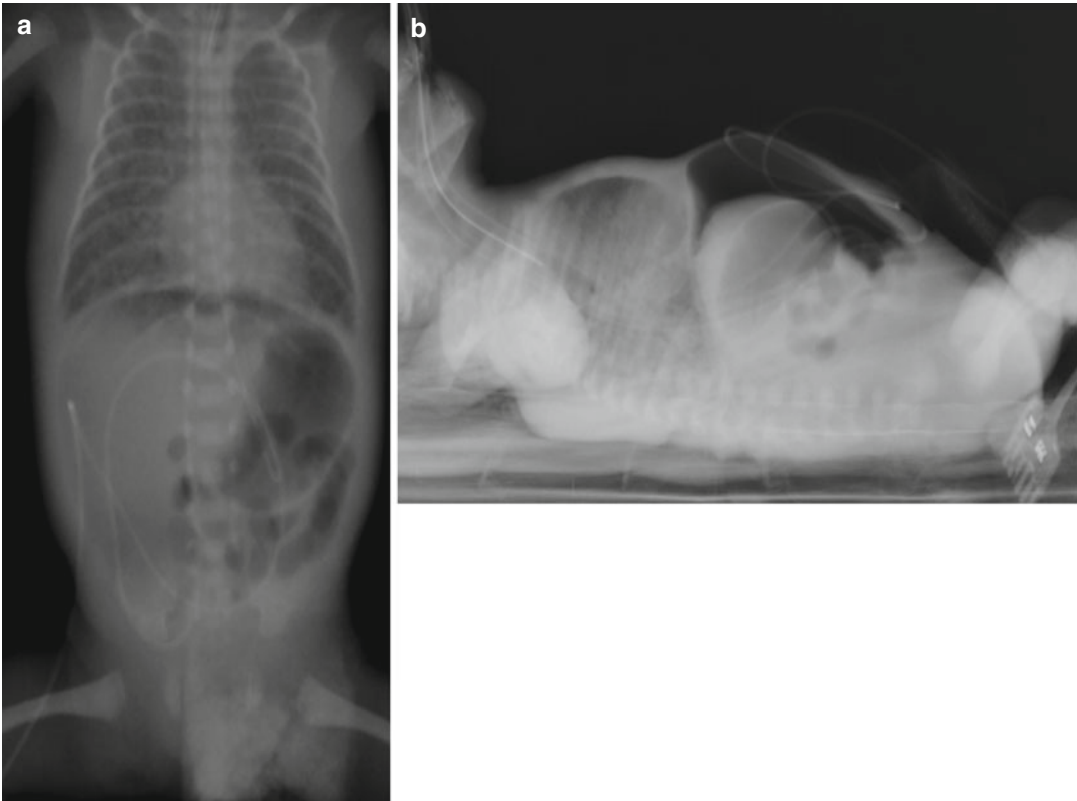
Abdominal plain film in newborn with NEC: massive pneumoperitoneum (a–b). In the frontal view (a) see the football sign and the continuous diaphragm sign
